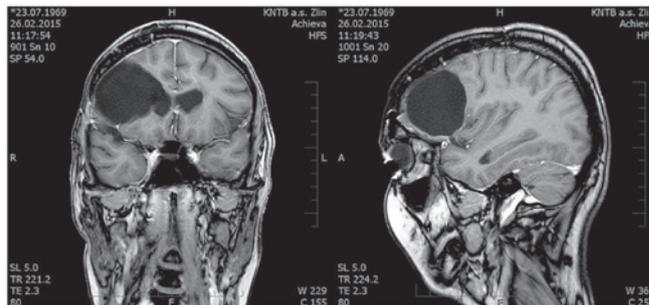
Postoperative magnetic resonance imaging coronar and sagittal scan (high- and area low-grade areas).
